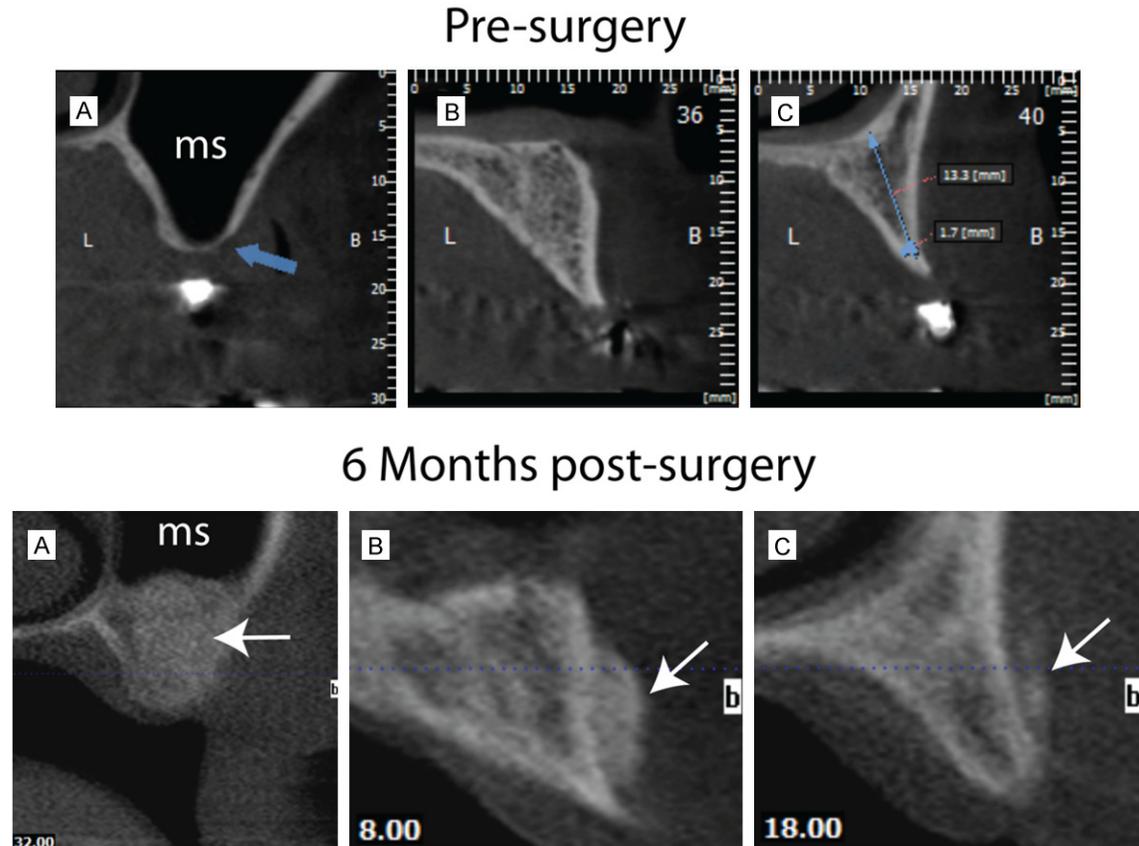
Pre and post-surgery CBCT images of edentulous maxillary with severe sinus bilateral pneumatization (“A” blue arrows in pre-surgery images from left side) and maxillary alveolar atrophy (pre-surgery images, “B” and “C” in Left side). The bilateral sinus lift by placement of mineralized cancellous bone allograft mixed with PRF and PRF membrane generated sufficient bone height (white arrows in “A” image in 6 months post-surgery images). Additionally, increase of the alveolar width was achieved (white arrows in “B” and “C” images in 6 months post-surgery images). ms: maxillary sinus.
